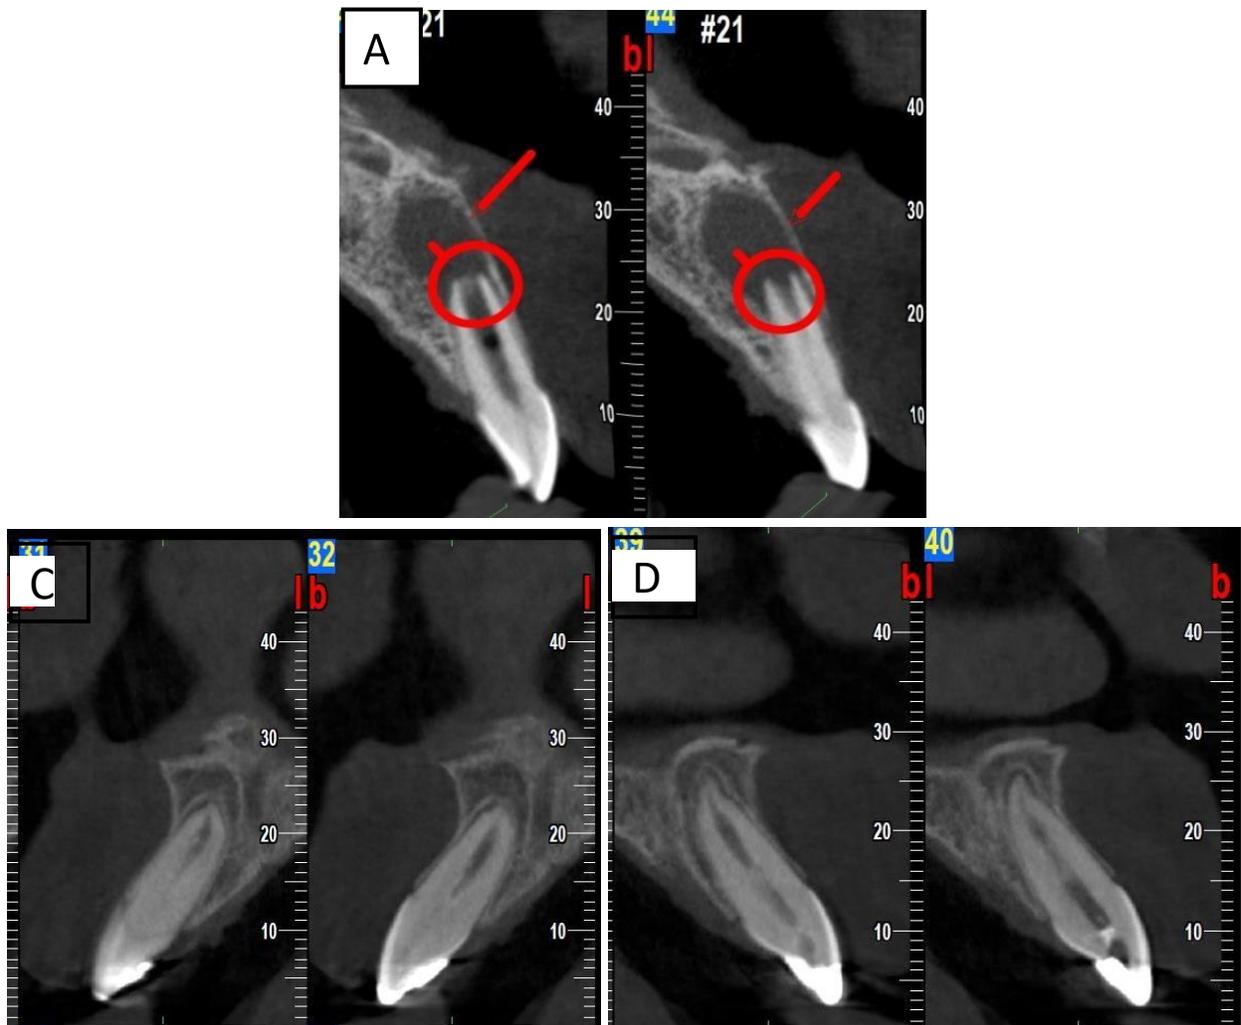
A) Pre-operative CBCT records showing open apices in relation to 21. B) and C) Post-operative CBCT record with evident root formation, closed apex and periapical healing in relation to 11 and 21 respectively
